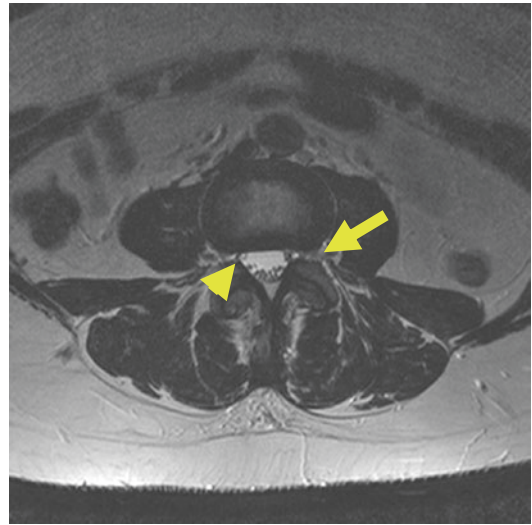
Axial T2-weighted image of the lumbar spine demonstrating the exiting nerve roots in the neural foramen (arrow) and the traversing nerve roots in the lateral recess (arrowhead)
